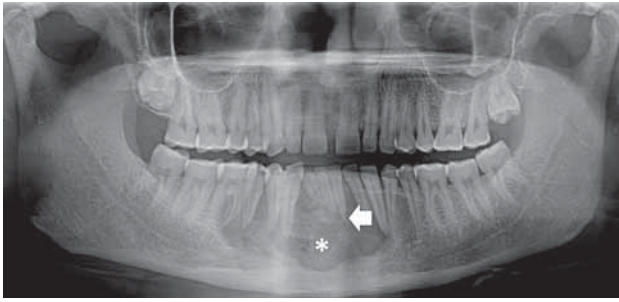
GCG of the mandible. Orthopantomogram shows an expansile, lytic central mandibular lesion with lobulated margins (*asterisk*). Note the resorption of the roots of the central incisors (*arrow*).
